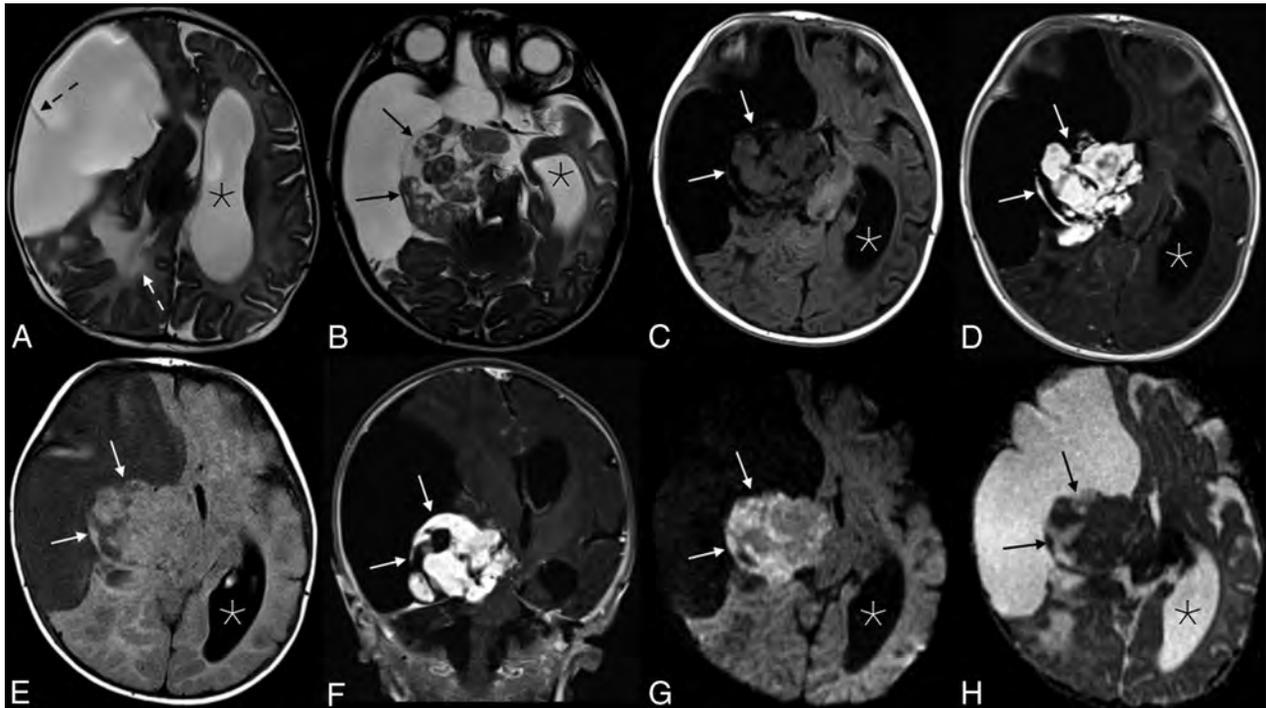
Appearance of the solid tumor component on various sequences. Axial T2 (A and B), axial T2 FLAIR (C), and T1 FLAIR (D) images showed a predominantly cystic mass in the right cerebral hemisphere with a heterogeneous solid component (black arrows in B, and H; white arrows in C–G) along the medial aspect of the tumor margin. A single thin septation was present within the cystic component (dashed black arrow, A). There is significant associated mass effect with T2 hyperintensity in the adjacent right parietal lobe white matter (white dashed arrow, A), a leftward midline shift, and compression of the right basal ganglia, brain stem, and right cerebral and middle cerebellar peduncles. The left lateral ventricle (asterisks) and third ventricle (not shown) were obstructed, causing marked ventricular dilation. Avid enhancement of the solid component is demonstrated in the axial (D) and coronal (E) T1WI + Gadolinium images. Heterogeneous mild intralesional restricted diffusion (G and H) is atypical for these tumors.
